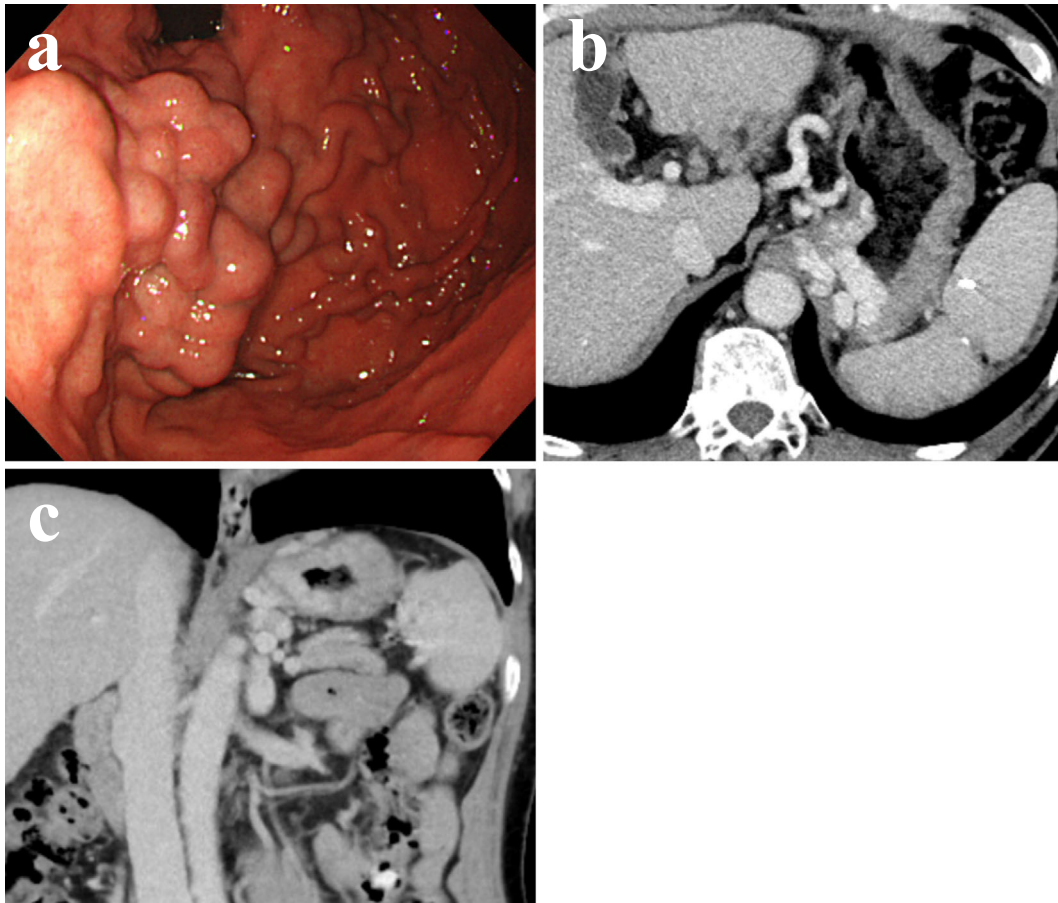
(a) Esophagogastroduodenoscopy (EGD) showed that the isolated gastric varices (IGVs) were white, large, and located in the cardia and fundus. (b, c) Dynamic computed tomography (CT) also showed that IGVs were in the cardia and fundus, suggesting that the left renal vein was the efferent vein.
